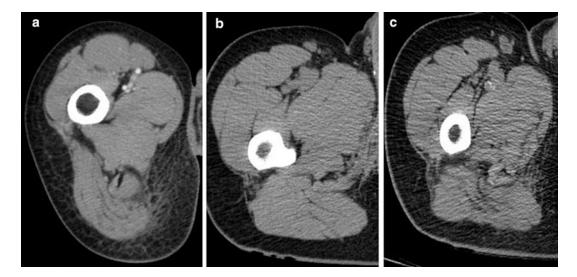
CT thigh of 15 years' male (a) 30 years old male (b) and 65 years old (c) showing 40% lost in muscle mass in between ages 15 and 65
